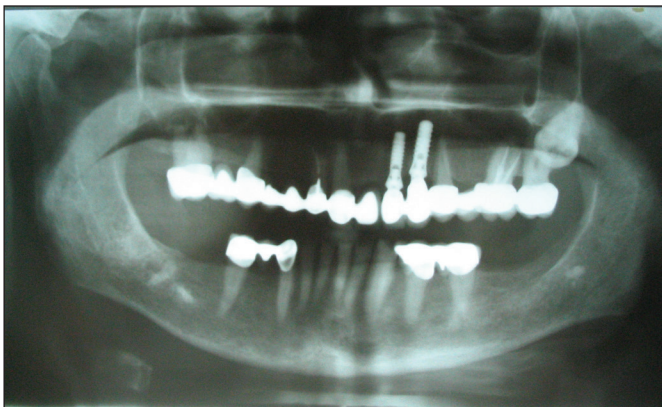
Panoramic radiography after 10 years.
